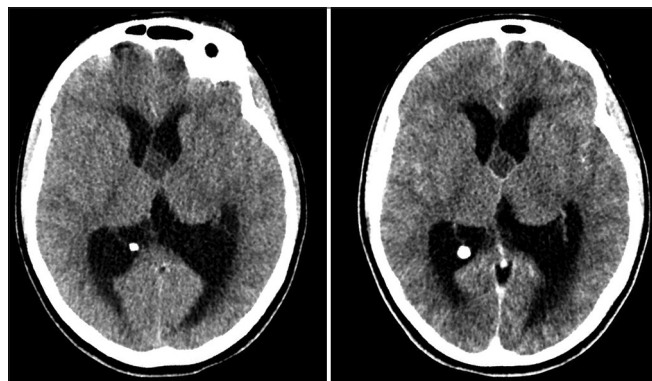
Preoperative computed tomography images showing acute hydrocephalus pre-contrast (left) and post-contrast (right) in axial view.
